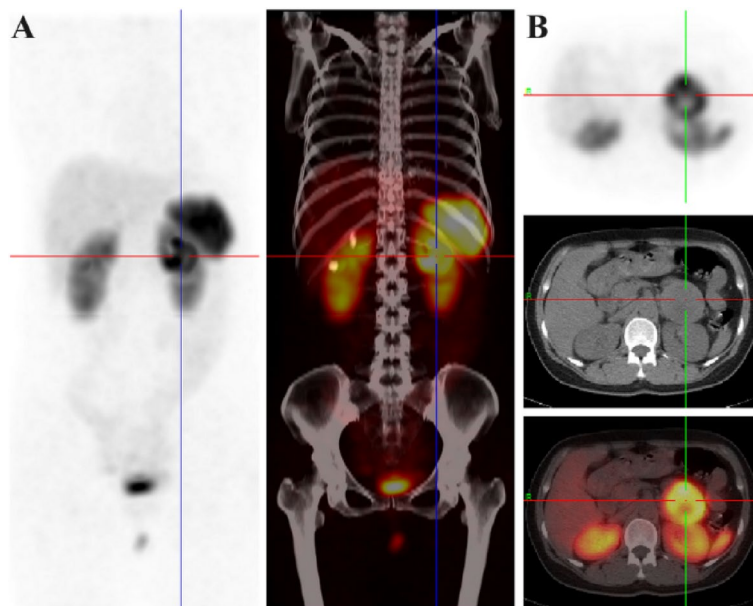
A 38-year-old female presented with headaches and paroxysmal hypertension. CT revealed a mass in the left adrenal gland. $[^{99m}\text{Tc}]\text{Tc-HYNIC-TOC}$ MIP image (A) shows an area of increased uptake of the radiotracer in the left adrenal region. The fused SPECT/CT image (B) demonstrates a left adrenal mass with a maximum diameter of 5.5 cm. The mass exhibits significant uptake of $[^{99m}\text{Tc}]\text{Tc-HYNIC-TOC}$, with a KS of 4 and a TBR of 7.07. The patient underwent surgery, and the diagnosis of pheochromocytoma was confirmed.
